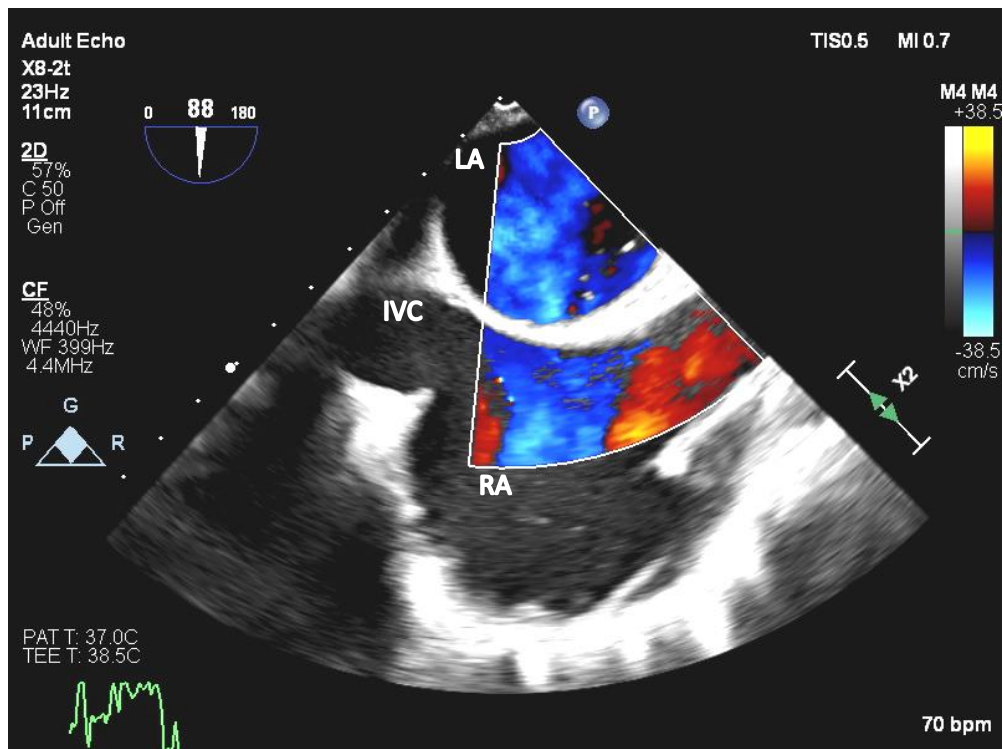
Midesophageal bicaval view with color flow Doppler over the interatrial septum showing no atrial septal defect or patent foramen ovale. RA, right atrium, LA, left atrium, IVC, inferior vena cava.
